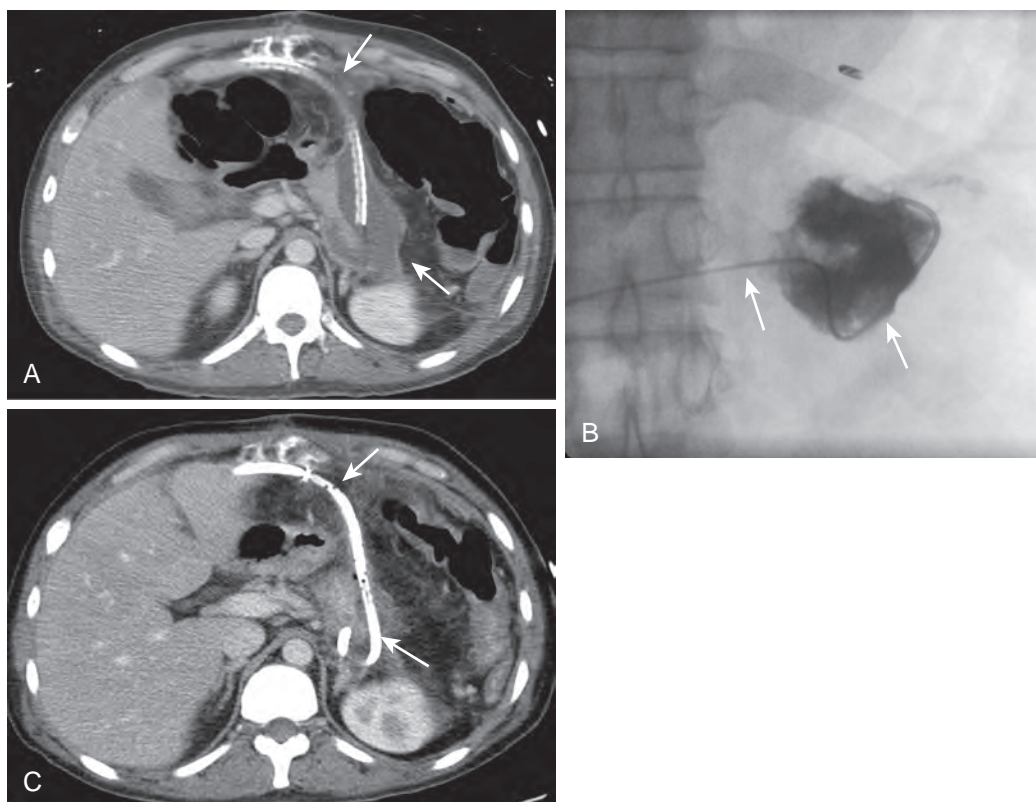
Use of surgical drain as an access for percutaneous drainage. A. Contrast-enhanced CT image shows a postoperative abscess (arrows) in the pancreatic bed not effectively drained by a surgical drain. B. Under fluoroscopic guidance, a guidewire was passed through the surgical drain to gain access into the abscess cavity. A Kumpke catheter was then passed over the wire into the abscess. Injection of contrast material in the image shows the peripancreatic abscess (arrows). C. Subsequently, the Kumpke catheter was exchanged for a wire, and a 12F multi-side hole drainage catheter was placed into the deep peripancreatic abscess with decompression of the abscess cavity (arrows).
